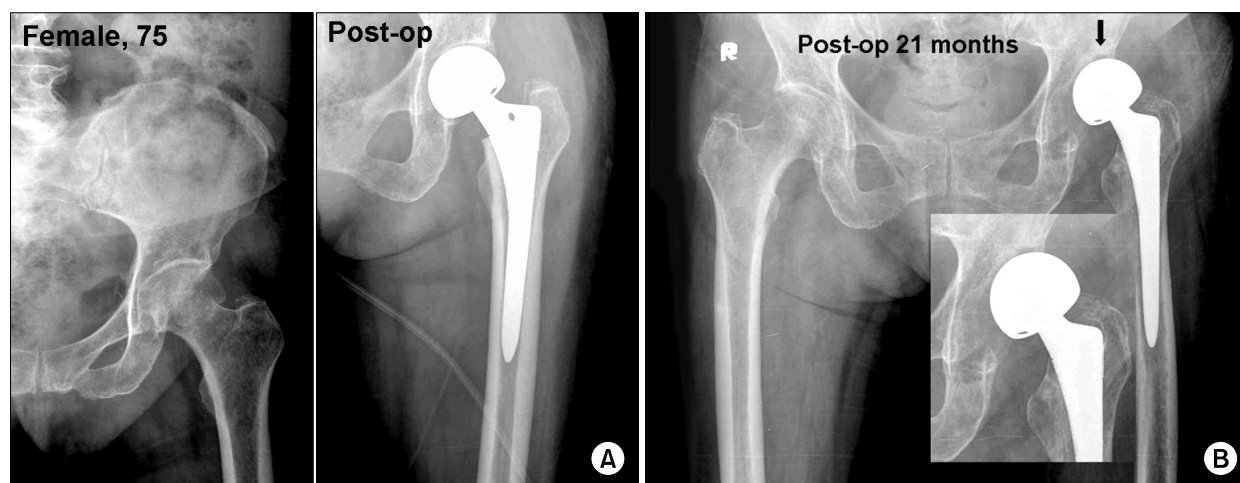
(A) AP radiograph of the pelvis of a 75-year-old woman with Bipolar hemiarthroplasty in left hip. Postoperative radiograph shows 18 months, the Harris hip score was excellent. (B) AP radiograph of the pelvis at postoperative 21 months shows the upward migration of the bipolar cup. The Merle d'Aubigne and Postel classification was 3 in the pain factor and 3 in the walking ability factor.
